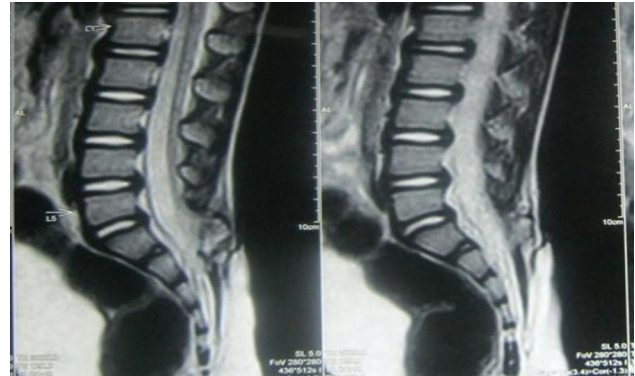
Radiological (magnetic resonance imaging) image of tethering of cord to dermal elements at lumbosacral level.
